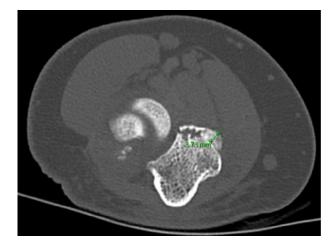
An axial cut of the coronoid was obtained from 2-dimensional computed tomography images to measure the maximal fragment size and displacement in the coronal plane.
